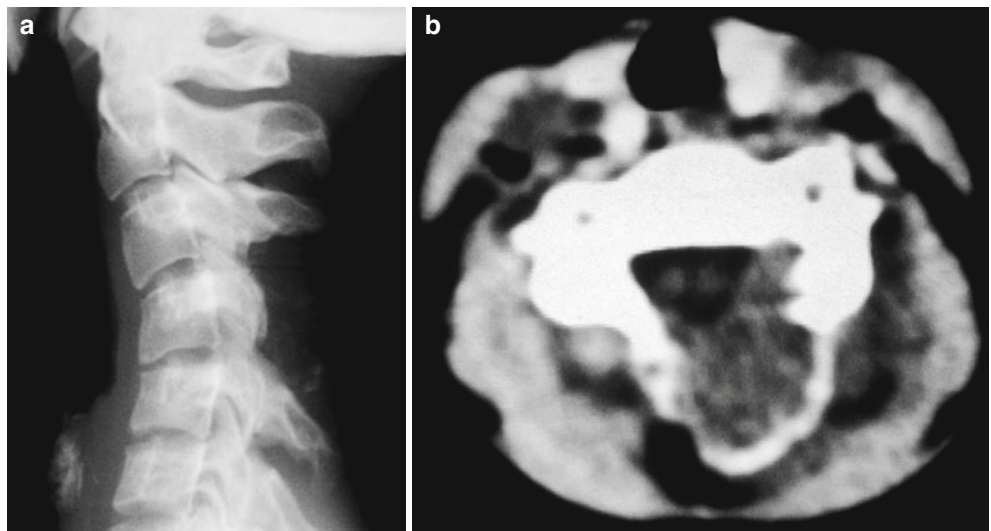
(a) Osteoblastoma in vertebral column tends to involve the posterior elements, similar to aneurysmal bone cyst. (b) Osteoblastoma in spine is best visualized by CT scan
